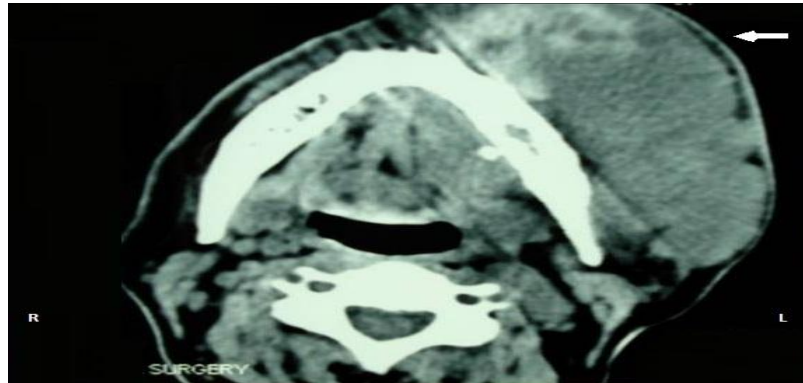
CT scan showing a large soft tissue mass on buccal mucosal aspect.
